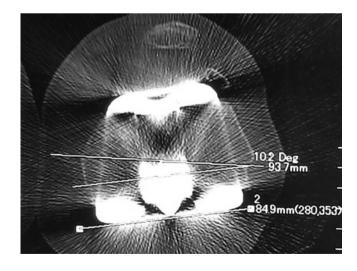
Preoperative measurement of rotational positioning of the femoral component using CT scan
